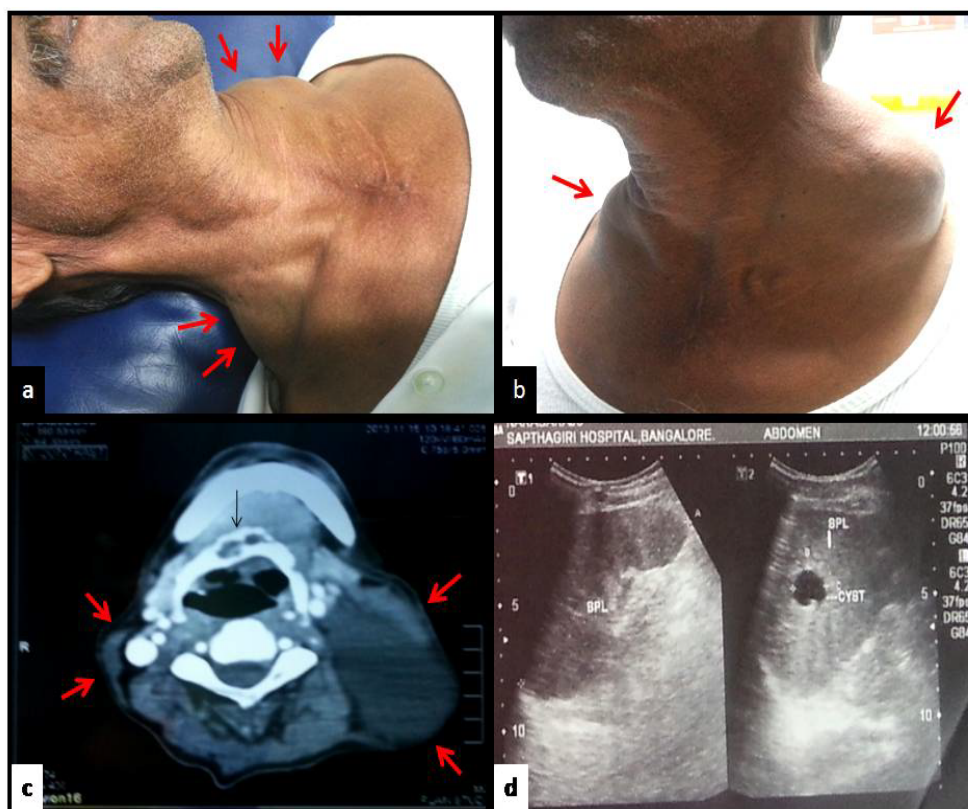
1a and 1b) clinical picture showing bilateral cervical swellings. 1c) CT image showing cystic masses in the bilateral cervical area and osteolytic lesion in the hyoid bone. d) ultrasonography showing splenic cyst.
